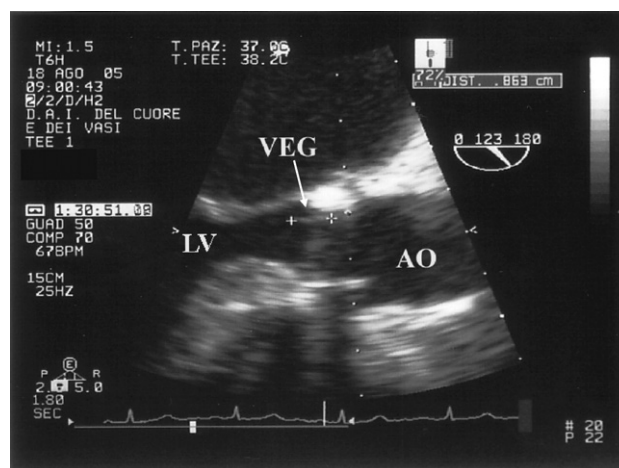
Echocardiographic transesophageal image. Elongated mobile vegetation attached to the aortic annulus is presented. Abbreviations: LV — left ventricle, AO — aorta, VEG — vegetation.
